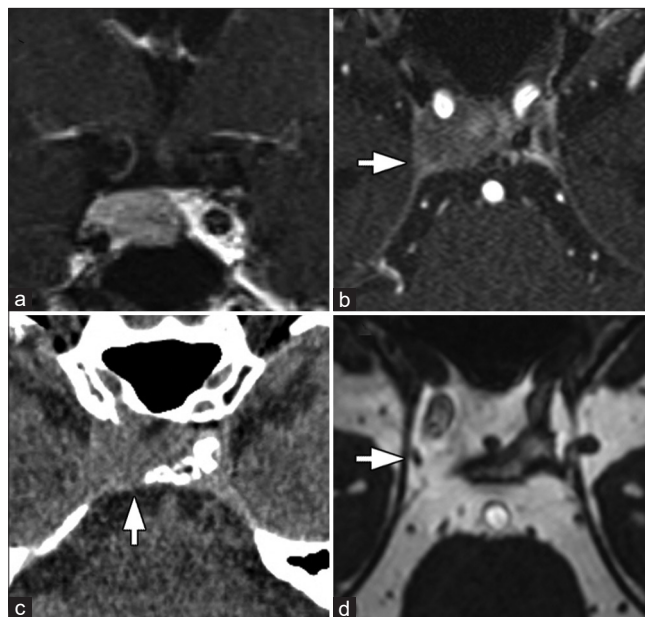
(a) Coronal gadolinium-enhanced T1-weighted image (Gd-T1WI) on magnetic resonance (MR) imaging showing homogeneously enhancing pituitary tumor with no evidence of intratumoral hemorrhage. (b) Axial Gd-T1WI showing latero-posterior tumor extension to the right cavernous sinus (arrow). (c) Computed tomography scan showing erosion of the right posterior clinoid process (arrow). (d) Postoperative constructive interference in steady-state MR image showing the right oculomotor nerve at the oculomotor triangle (arrow).
